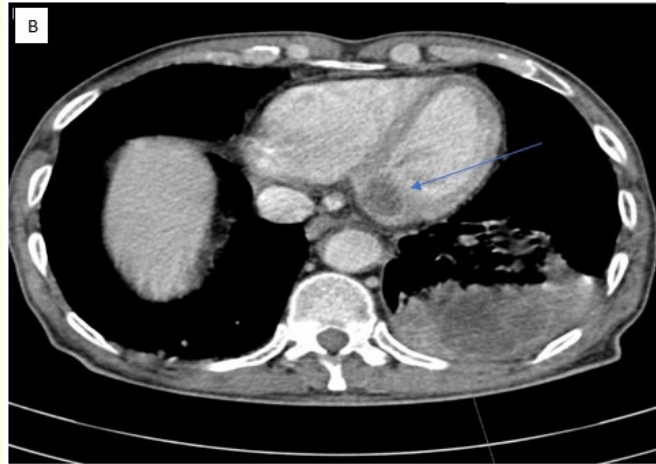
Axial CT scan image in the mediastinal window before (A) and after contrast (B), showing the secondary mass of the left ventricle (Arrows), due to the left lower lobe pulmonary adenocarcinoma (Arrowheads).
